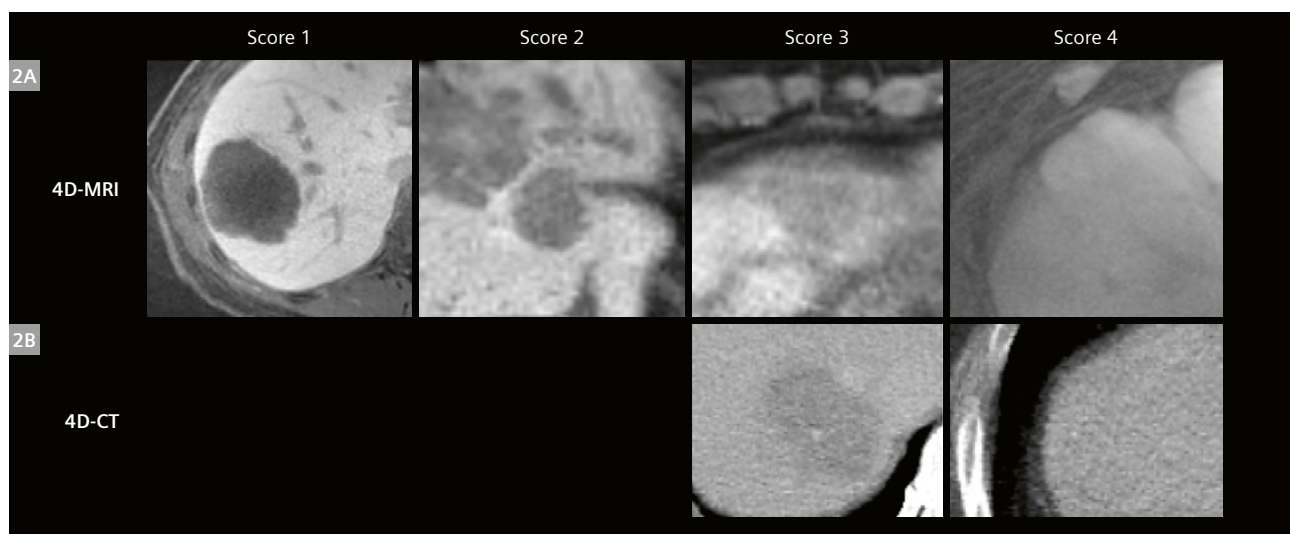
Image quality was assessed using a 4-point clarity score, with lower clarity scores corresponding to superior image quality, as shown in Figure 2. Clarity scores were significantly better for 4D-MRI versus 4D-CT (1.2 ± 0.4 and 3.5 ± 0.7 , respectively, $p < 10^{-9}$). No liver tumors were rated 4 on any 4D-MRI because all lesions were definable on all phases regardless of the binning algorithm. No liver tumors were rated 1 or 2 on any 4D-CT.
